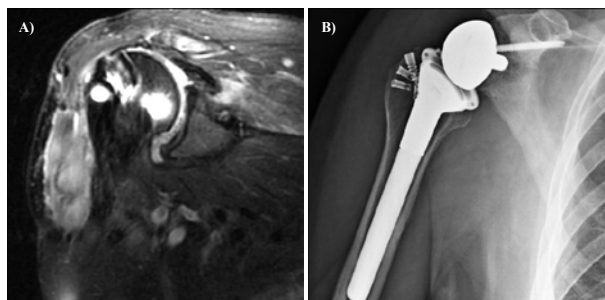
Patient A continued to have significant pain despite his rotator cuff repair and gradually developed anterior superior escape. At four months post-op another MRI was obtained which demonstrated a) failure of his rotator cuff repair. The patient's pain and inability to use the shoulder persisted despite a deltoid strengthening physical therapy trial and at 1 year post-injury the patient underwent b) reverse total shoulder arthroplasty.
